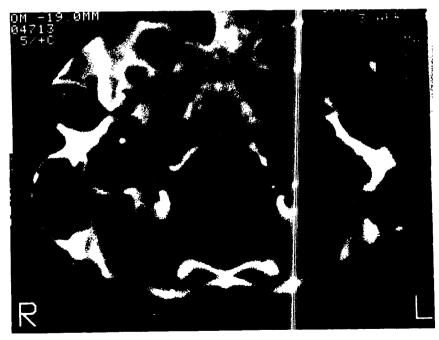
CT scan through the base of the skull showing erosion around the hypoglossal canal on the left side.
